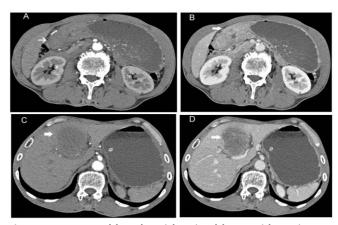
A 66 yr old male with Mixed hepatoid carcinoma. A, B Axial contrast enhanced CT scan with circumferential wall thickening (white arrow) with heterogeneous enhancement in pyloric part of the stomach in arterial and portal venous phase respectively. The tumor appears to involve the serosal layer of the stomach (T4a) with fat stranding around. C Shows liver metastasis (white arrow) from HAC of stomach with hypoattenuating, mostly homogeneous enhancing, ill-defined mass in arterial phase and portal venous phase (D).
